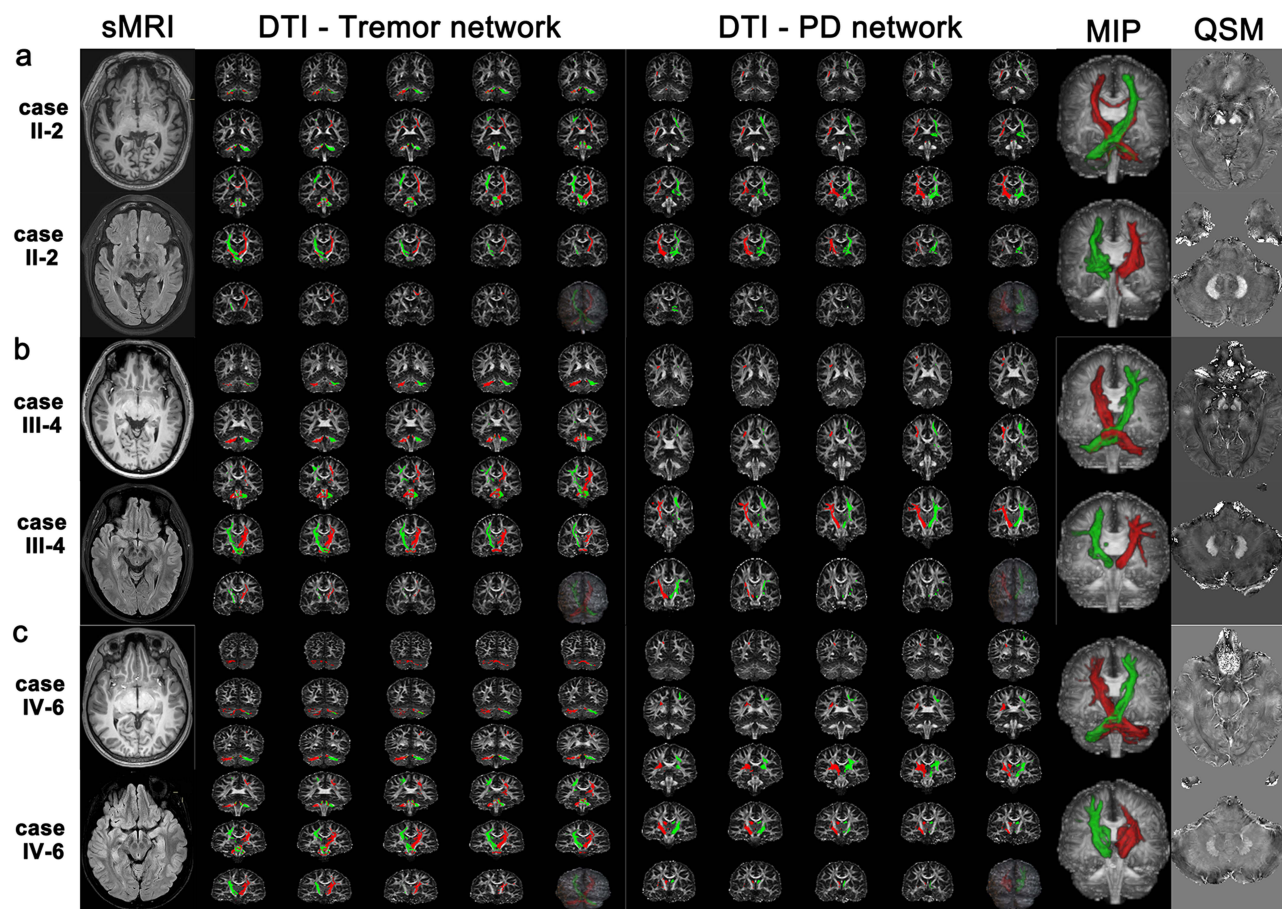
Multimodal imaging performed in the three generations. First column: sMRI; second column: DTI-Tremor network; third column: DTI-PD network; fourth column: DTI-MIP; and fifth column: QSM. (a). the multimodal MRI findings of the case II-2. (b). the multimodal MRI findings of the case III-4. (c). the multimodal MRI findings of the case IV-6.
